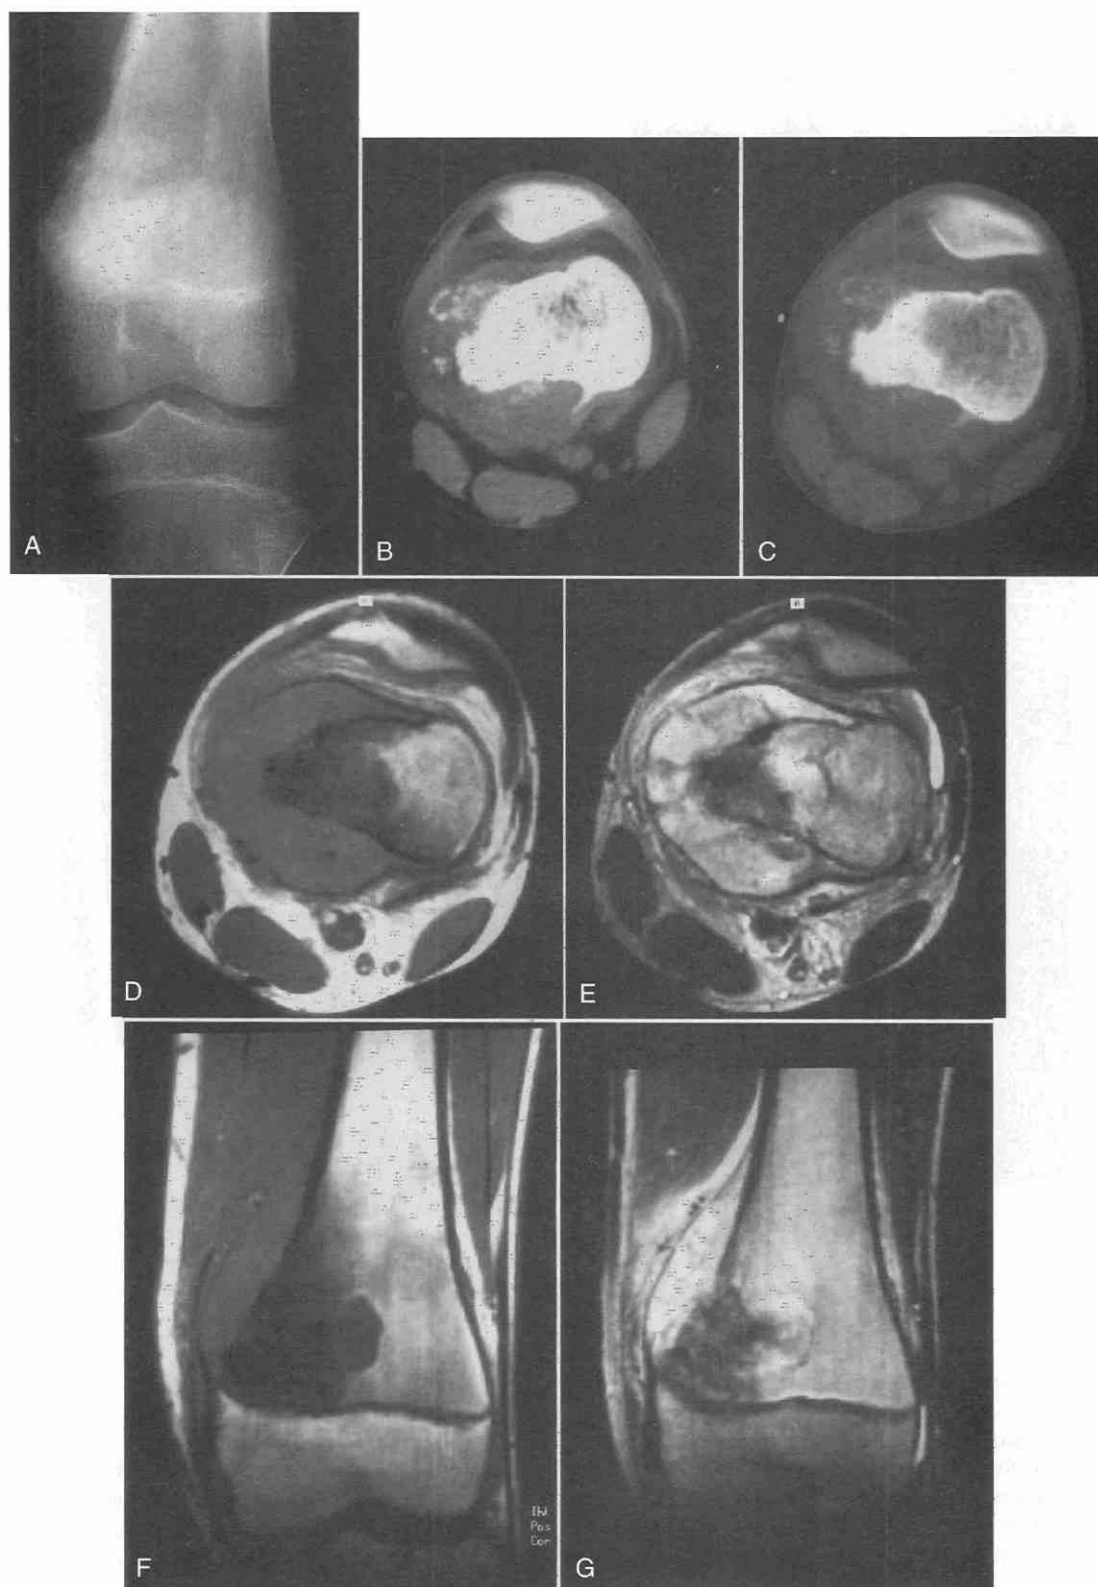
Osteosarcoma in the femur of a 14-year-old boy. Radiograph (A) demonstrates a sclerotic lesion in the metaphysis, with medial destruction of the cortex and periosteal reaction. CT images using soft tissue window settings (B) and CT images using bone window settings (C) reveal a sclerotic lesion of the medial aspect of the femur with an associated soft tissue mass and a periosteal reaction. Four MR images were obtained: two axial spin-echo views (TR = 500 msec, TE = 15 msec) (D) and (TR = 2000 msec, TE = 70 msec) (E) and two coronal spin-echo views (TR = 600 msec, TE = 15 msec) (F) and (TR = 2000 msec, TE = 70 msec) (G). The soft tissue component can be more easily visualized with MRI than with CT, but the periosteal reaction and soft tissue calcification are not as evident. An area of low signal intensity is present on both T1-weighted and T2-weighted images; it corresponds to the area of sclerosis seen on the CT scans.
